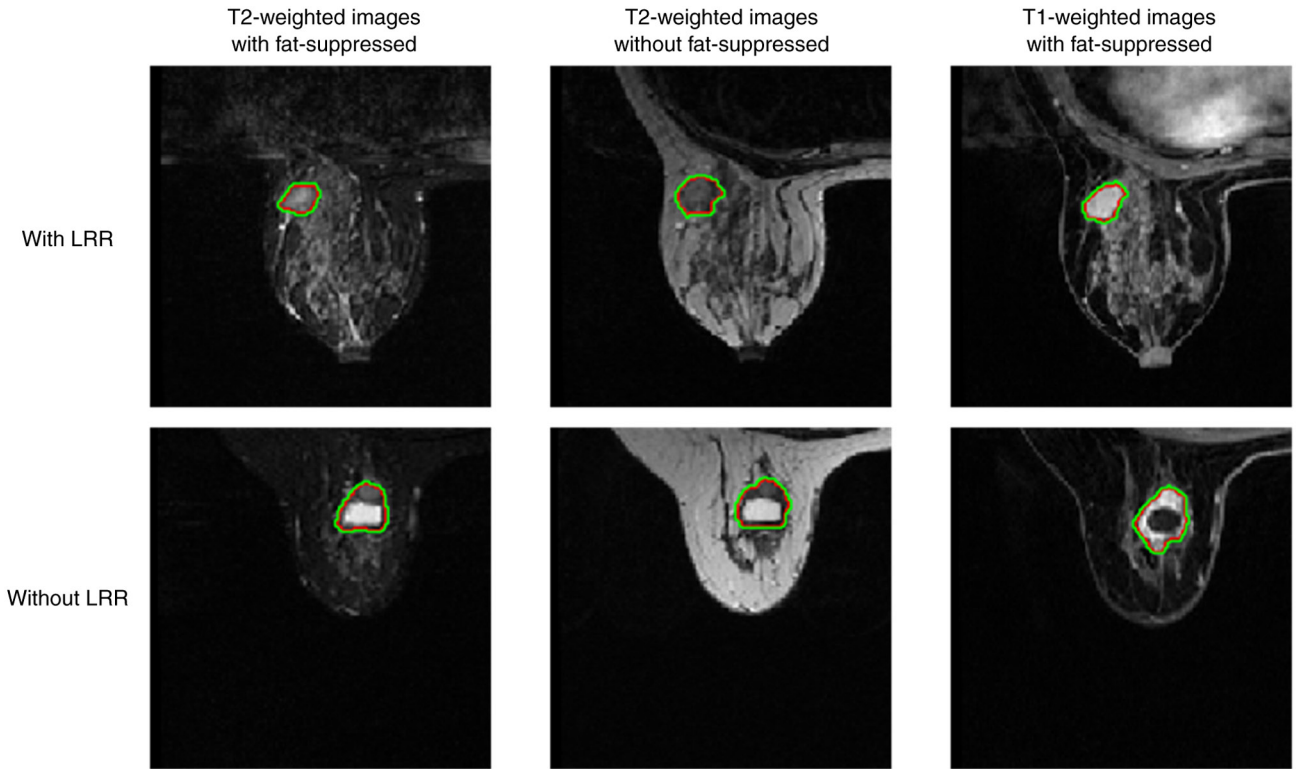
Examples of imaging. Three different magnetic resonance imaging sequences are presented. The first row presents cases without LRR, and the second row presents cases with LRR. In each image, red represents manual contouring, and green represents a 1-mm expansion of the contour. LRR, locoregional recurrence.
